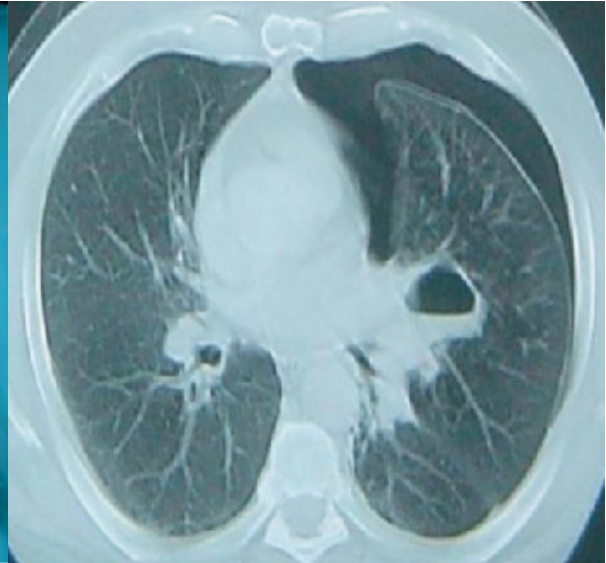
CT scan of patient
